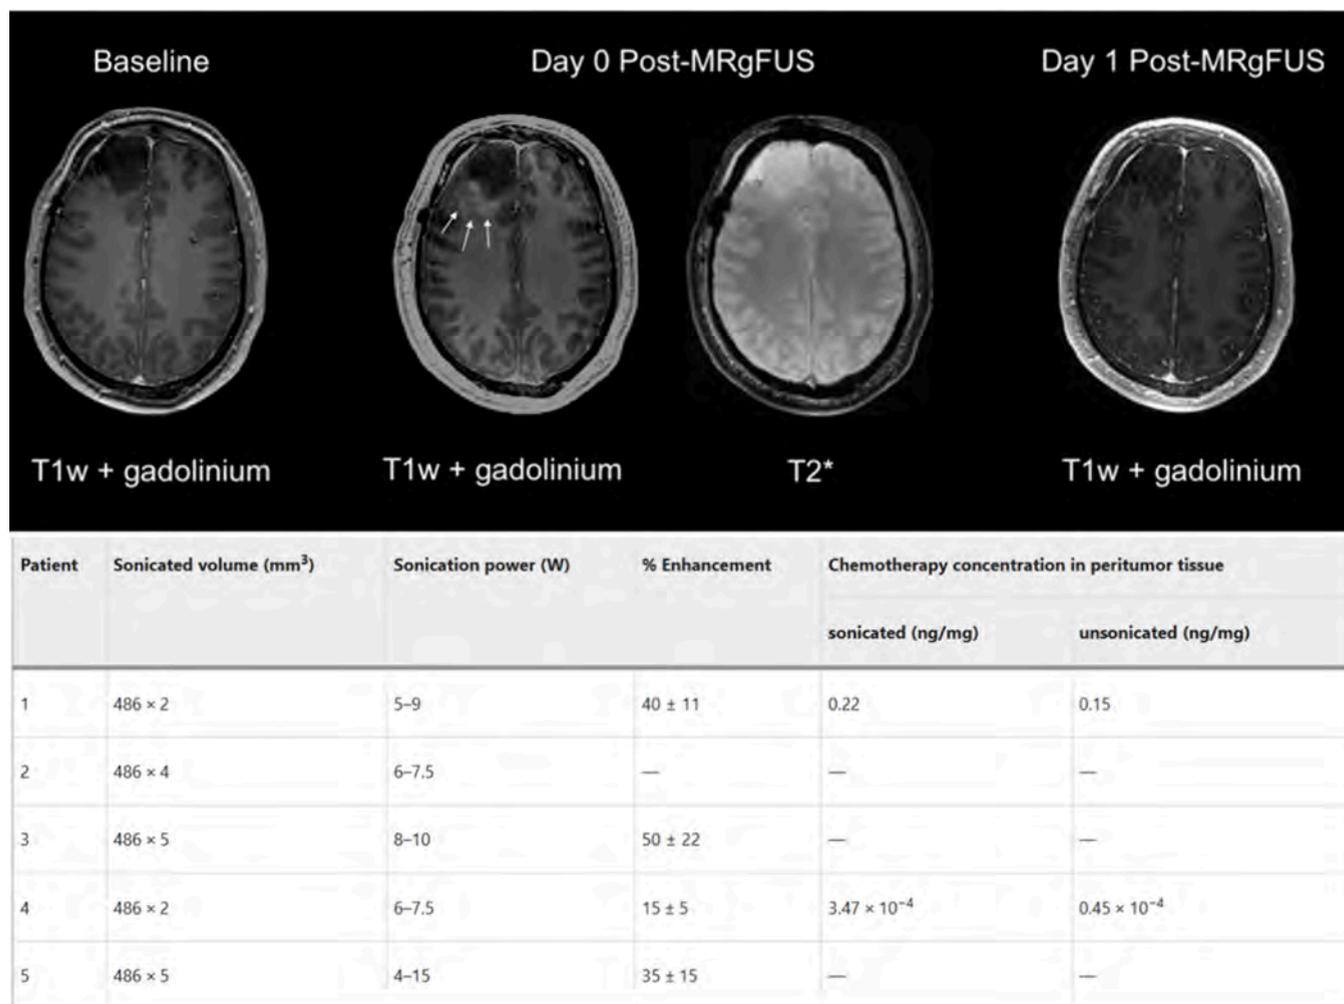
MRI of BBB disruption. The BBB was safely and successfully opened in the five patients enrolled, as shown by postsonication gadolinium enhancement in the target region and resolution 24 s. Sample T1-weighted postgadolinium MRI from patient five obtained 30 days prior to BBB opening procedure (left), immediately following BBB disruption (middle), and 20 h after BBB disruption (right). Ill-defined contrast enhancement is seen in the peritumoral region on images acquired immediately after MRgFUS (white arrows). This contrast enhancement has resolved in the peritumor region on the day 1 follow-up image indicating closure of the BBB. T2* sequence acquired immediately following BBB disruption for this patient show no evidence of microhemorrhages. The table indicates the percent change in signal intensity in the region of interest (sonicated) relative to adjacent nonenhancing tumor margin tissue in the ipsilateral hemisphere. Reproduced from ref 25. Available under a CC-BY license.
